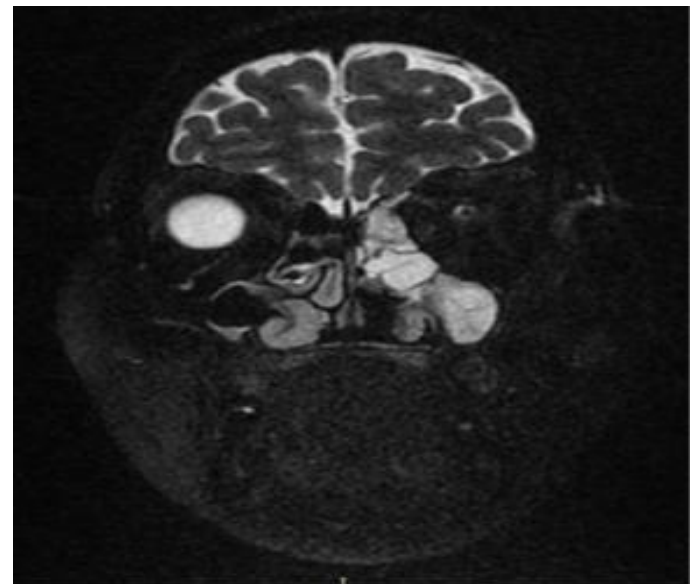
Sino - nasal involvement in post COVID mucormycosis. Coronal T2 fat sat. MR image shows mucosal thickening with internal hypointense contents along bilateral maxillary and ethmoid sinuses, more prominent on left side.
